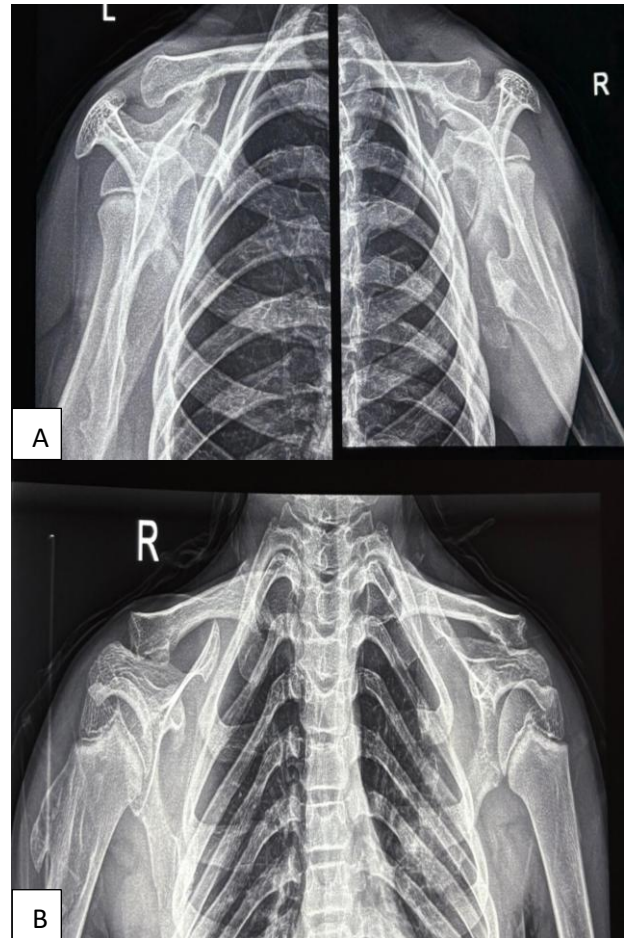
Plain radiographs of bilateral shoulders with scapula (A) scapular Y view and (B) anteroposterior view.
